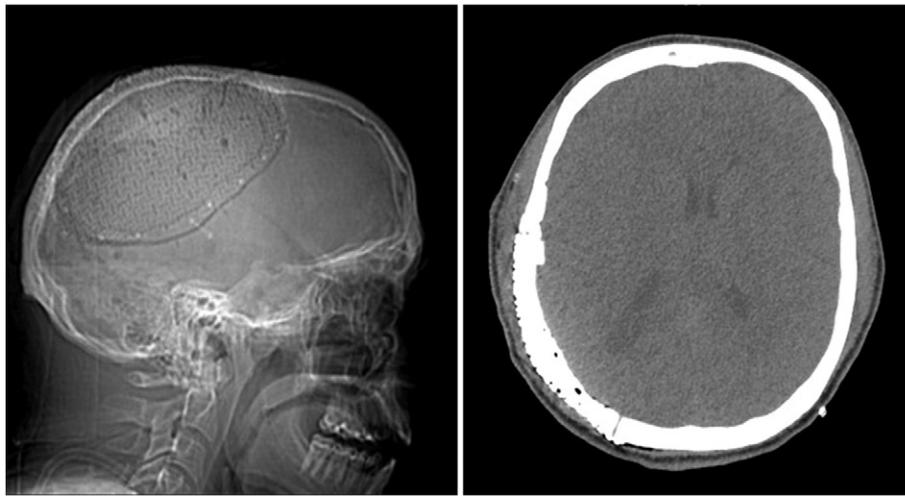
The in situ cranioplasty is demonstrated on lateral x-ray (left panel) and axial non-contrast CT scan (right panel).
